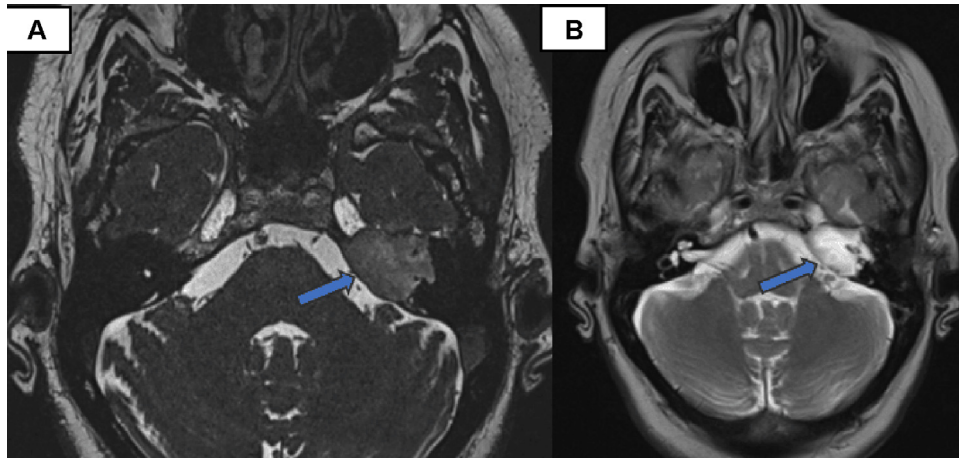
(A) MRI 3D CISS sequence showing an intermediate signal mass of the left petrous apex (Blue arrow). (b) MRI Axial T2 showing a mass of the left petrous apex exhibiting a high signal (Blue arrow).
